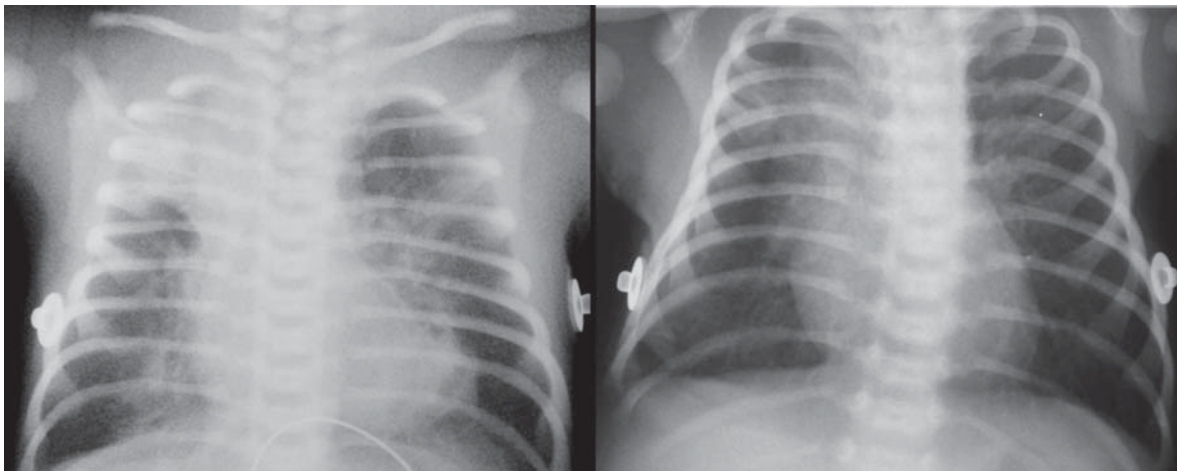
(a) Chest radiography on the 5th day of life showing bilateral streaky opacities, diffuse patchy infiltrates and consolidation of the right upper lobe; (b) Repeat chest radiography on the 16th day of life revealing resolution of pulmonary infiltrates.
